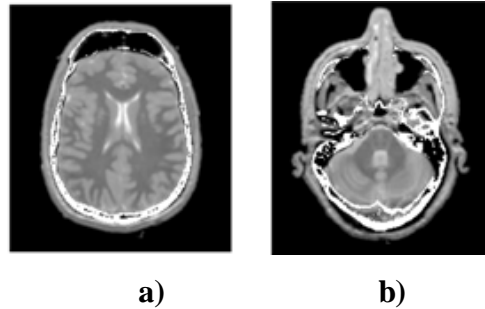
2 Fused images using the XOR operator: a) CT information (bone structures), b) superimposed on two registered MR transverse slices. [53]
